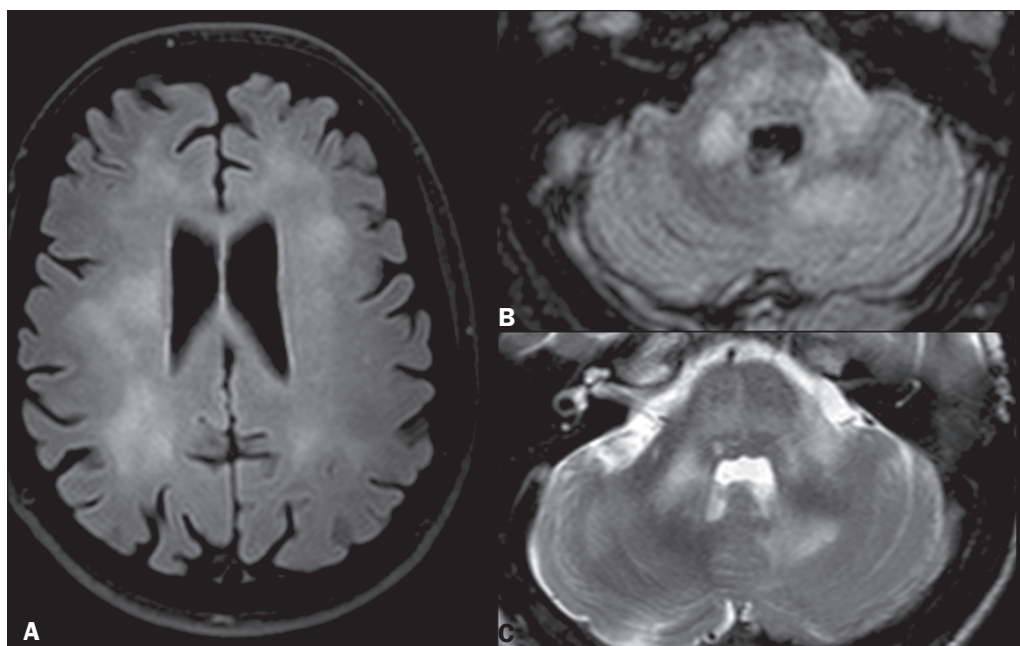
PML. A: Axial FLAIR sequence showing periventricular and subcortical white matter lesions, with no mass effect. T1WI after contrast (not shown) revealed no enhancement. Axial FLAIR sequence (B) and T2WI (C) showing pontine and cerebellar white matter lesions, as well as hyperintensities in both MCPs.
